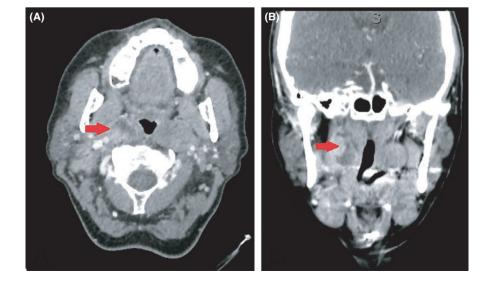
Contrast-enhanced CT scan of the neck (A: axial view; B: coronal view) depicting right tonsillar mass with an associated 2.8 cm fluid collection (red arrow). Additionally, a right level II/III necrotic nodal conglomerate measuring up to 5.4 cm was noted
